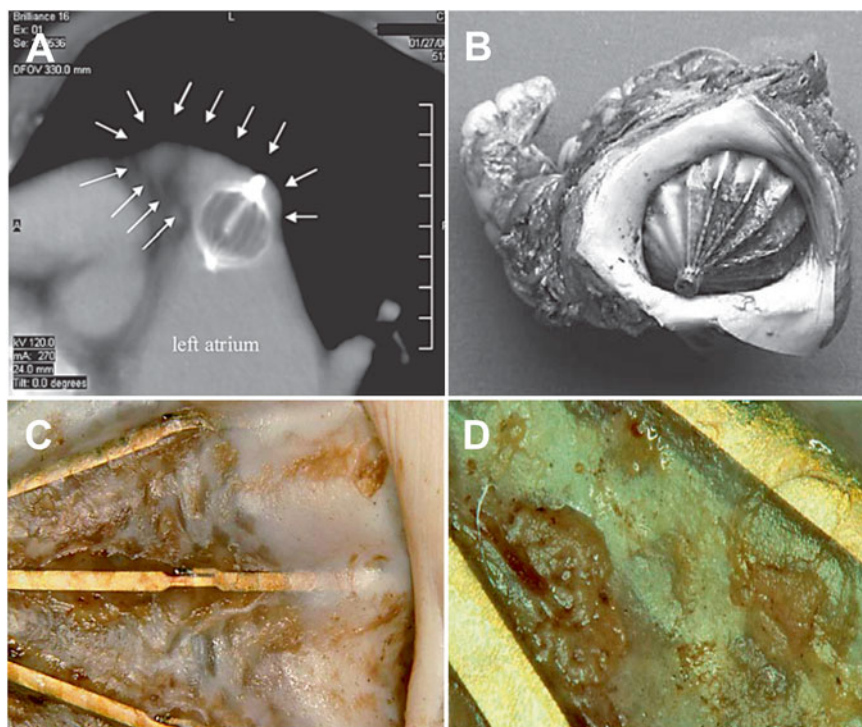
Postmortem analysis of the PLAATO device with thromboembolism. Cardiac CT of the PLAATO device 3 months after implantation (a). The arrows frame the LAA and demonstrate a partially protruding PLAATO device into the LA. Despite the rotation of the device, the gross examination reveals that the LAA orifice is completely occluded (b). Thrombotic deposition is seen on the atrial surface of the PLAATO device at 1:8 magnification (c) and 1:18 magnification (d). Adapted from Park et al. [23] with permission from *Cardiology*
